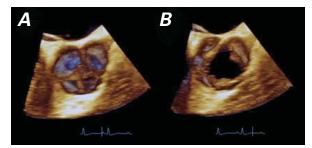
Transesophageal echocardiograms (3-dimensional shortaxis views) show the A) closed and B) open quadricuspid aortic valve.
